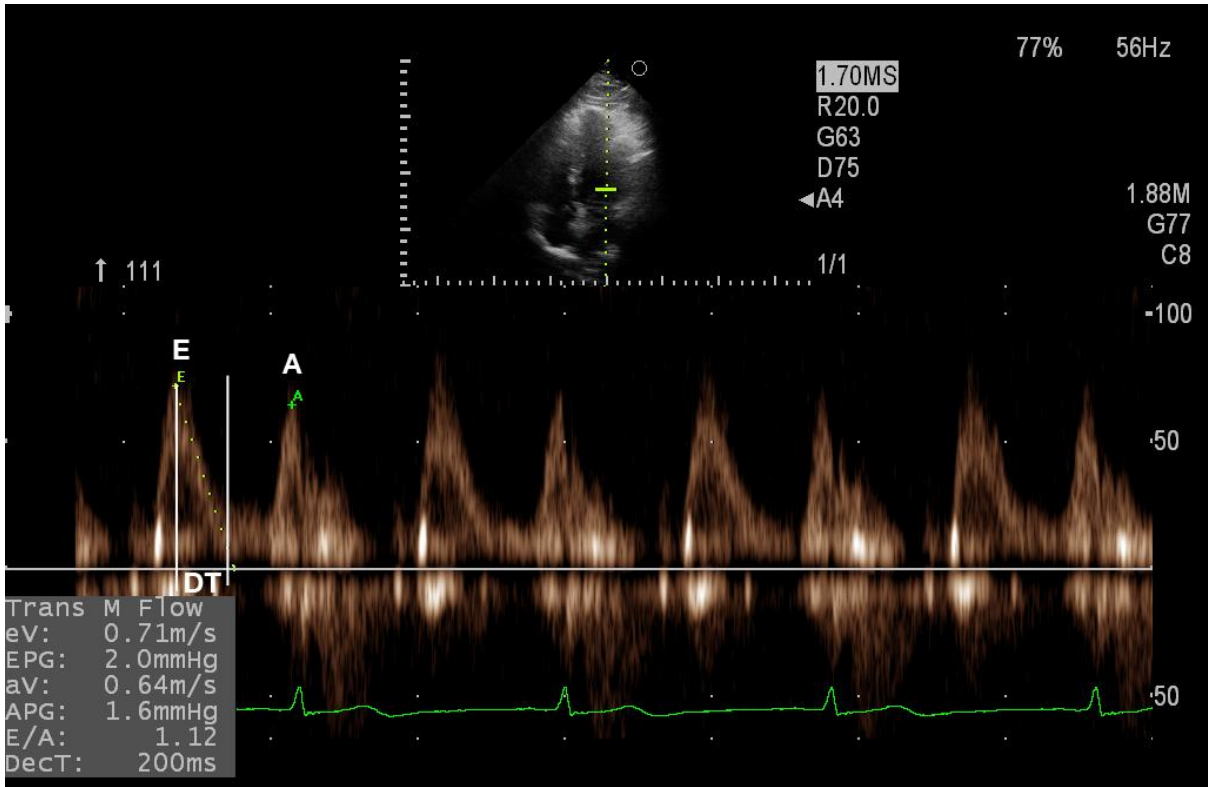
Mitral inflow velocities examination. Pulsed wave Doppler (PW-Doppler) allows the measurement of velocities at the level of the sample volume. Two flow velocity envelopes can be seen during diastole in persons with sinus rhythm: the E-wave, representing the early, passive filling of the left ventricle, and the A-wave, that happens late in diastole, representing the active filling, the atrial contraction.
